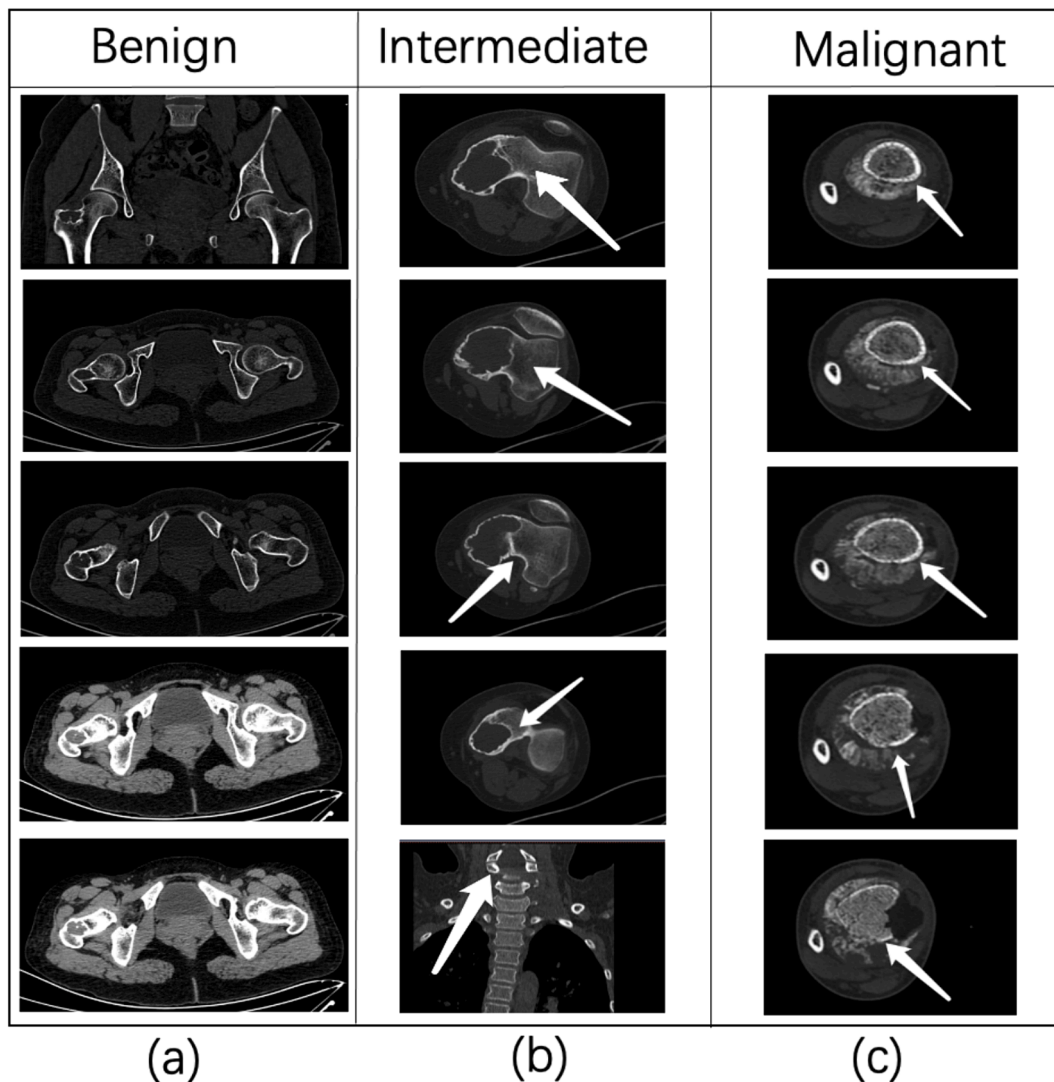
Partial display of a dataset containing CT images of the tibia and femur. Part a represents a benign bone tumor; part b represents a neutral bone tumor; and part c represents a malignant tumor. The white arrows point to the location of the tumor.
